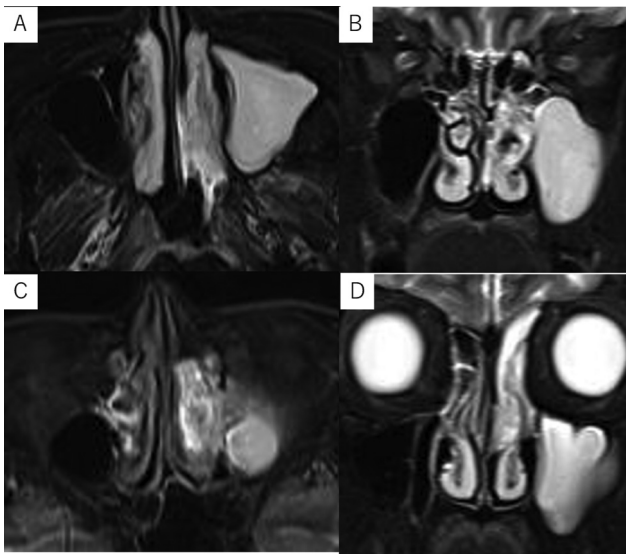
Plain magnetic resonance imaging (MRI) of the paranasal sinus (T2 short-term inversion recovery). (A, C) Axial and (B, D) coronal sections. High signal intensity with relative uniformity is shown in the left maxillary sinus and frontal sinus. A partial region of high signal intensity is shown in the left ethmoidal sinus.
